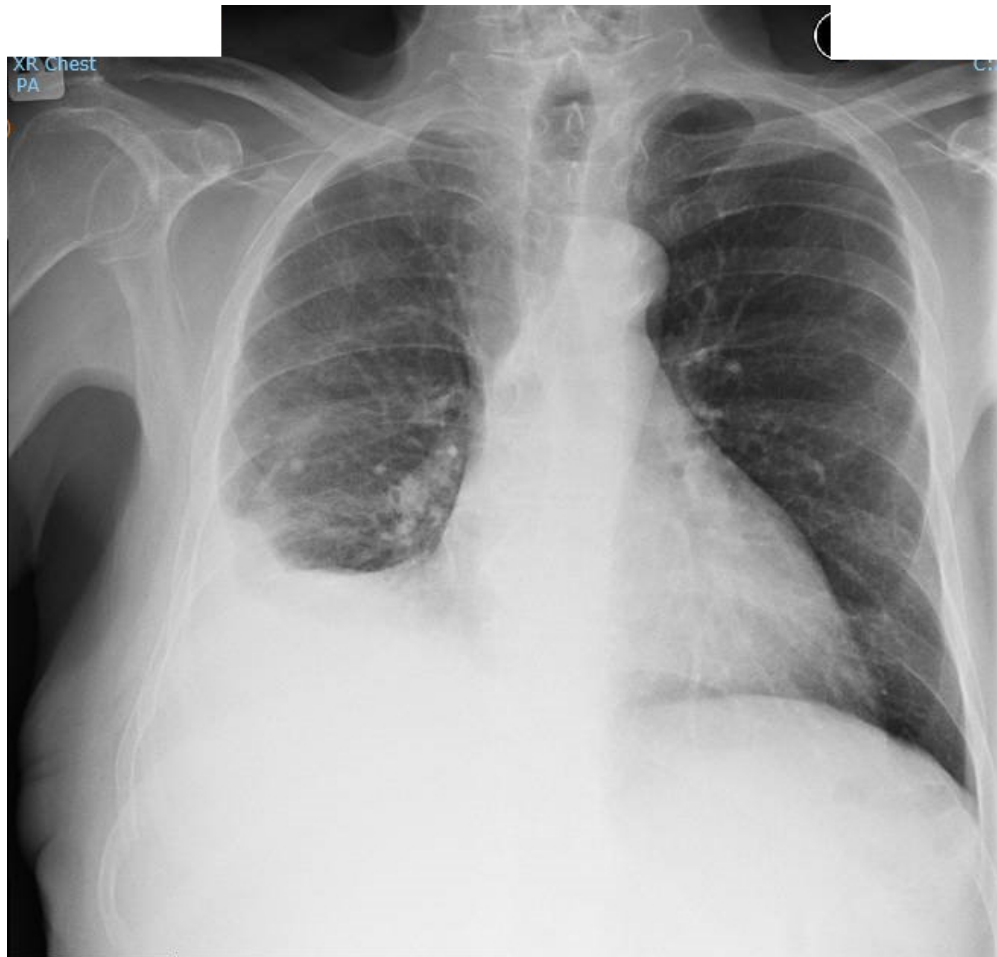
Chest radiograph of a 74-year old male who was diagnosed with GI-NET in 2015 and found to have elevated NT proBNP, which was attributed to age and hypertension without evidence of CHD. He remained under follow-up, developing tricuspid regurgitation that became severe and was associated with breathlessness. He was found however, to have a right pleural effusion that was exudative, without cellular infiltrate and with normal high-resolution computed tomogram and with normal thoracoscopy.
